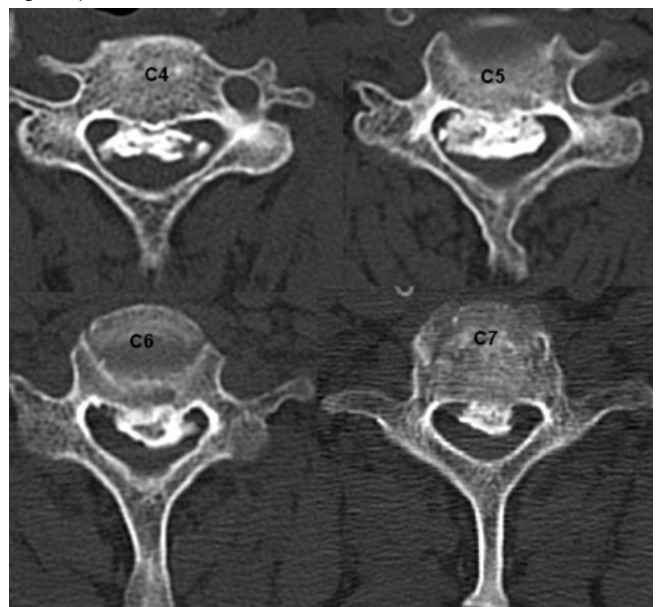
Cervical axial CT: Severe spinal canal narrowing at C3, C4, C5, C6 and C7 vertebral body levels due to OPLL.
